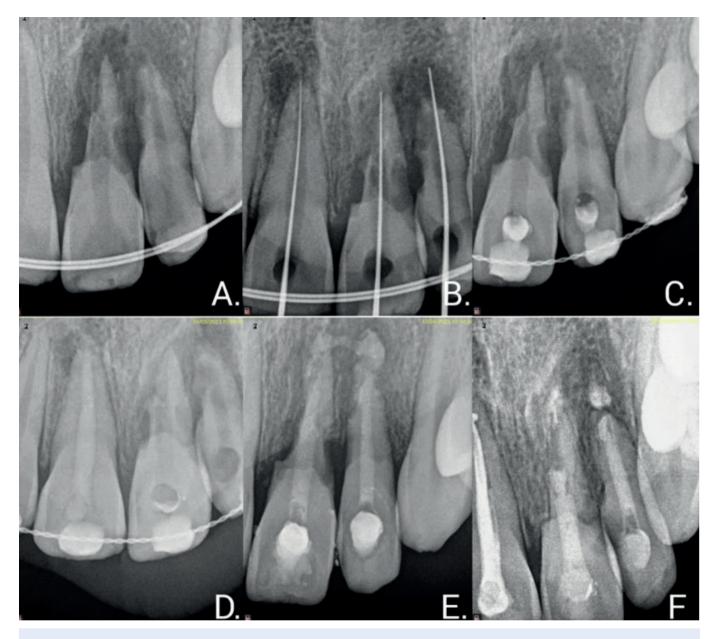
Radiographic image: A. Pre-operative radiograph B. Working length determination C. Intracanal medicament placement with CaOH placement in relation to 11 and a combination of Triamcinolone acetonide, doxycycline, and metronidazole placed in relation to 21 and 22 D. Splinting at the end of 14th day. E. After obturation. F. 12 months follow up.
